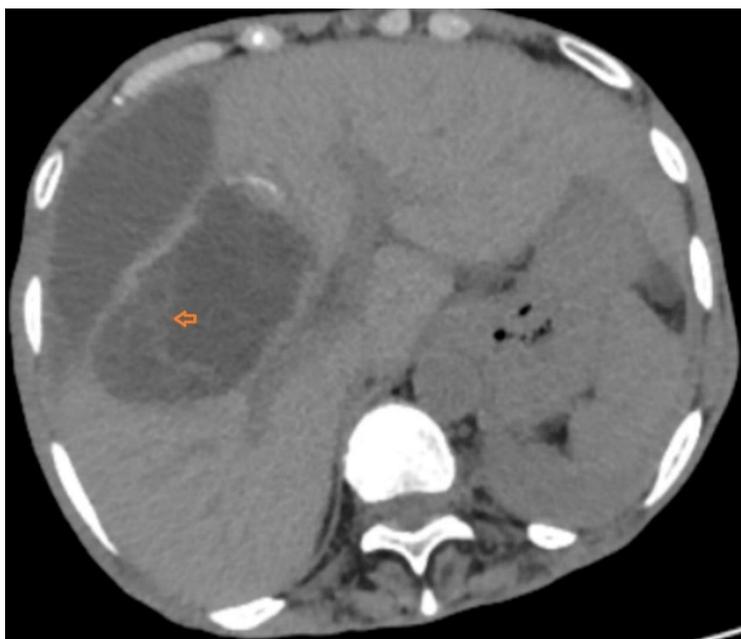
Non contrast CT, Axial section: showing a well defined cystic lesion with thin walls and internal laminated septations(orange arrow mark).
